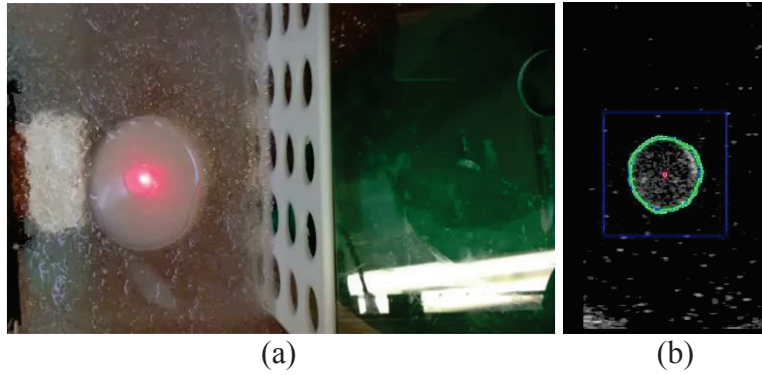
(a) Motion tracking effect shown by laser beam and (b)ultrasound image tracking
